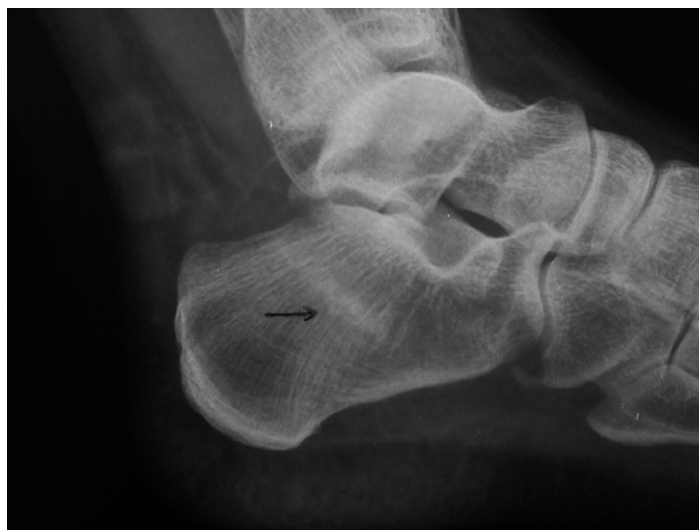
A right lateral radiograph showing a subtle sclerotic line oriented from posterosuperior to anteroinferior in the posterior calcaneus (arrow)
